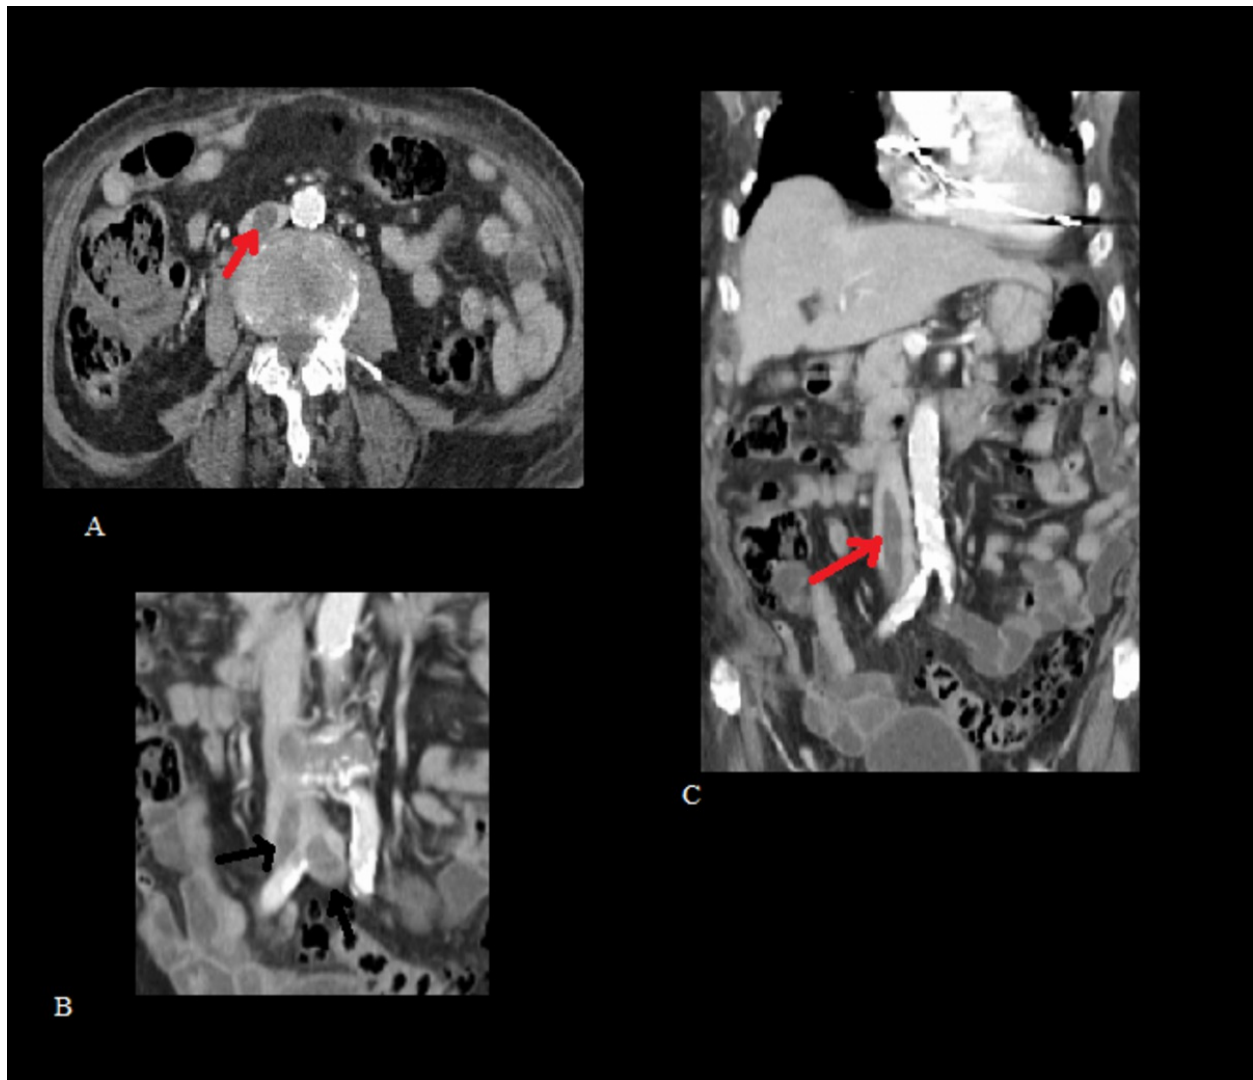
Infrarenal IVC bland thrombus:Axial and coronal enhanced computed tomography reveal a large filling defect of the IVC (red arrow)in a patient with lower extremitie thrombosis.
